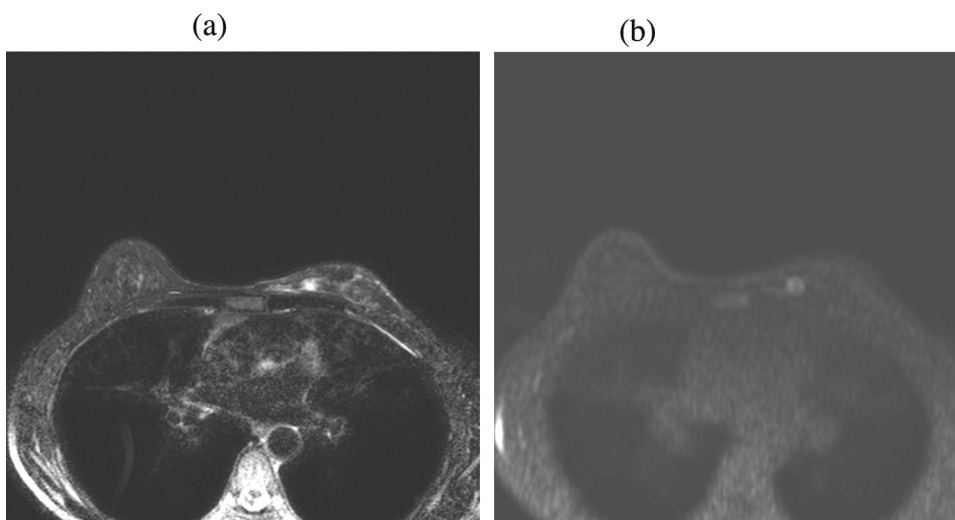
(a) Non-contrast MRI: T2WI. High intensity was observed at the center of the tumor. (b) Non-contrast MRI: DWI. Accumulation at the center of the tumor suggested inflammation or a malignant component.
